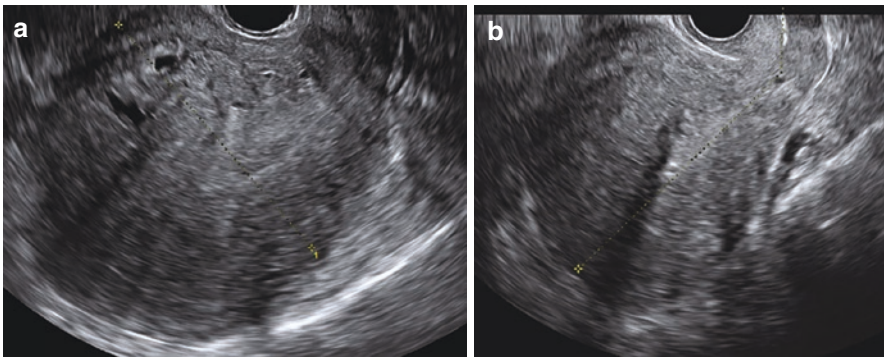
(a, b) Two ultrasound images of a globular uterus with diffuse adenomyosis. Gray scale image showing a globally enlarged uterus, asymmetrically thickening of the uterine walls, and abnormal myometrial echogenicity
